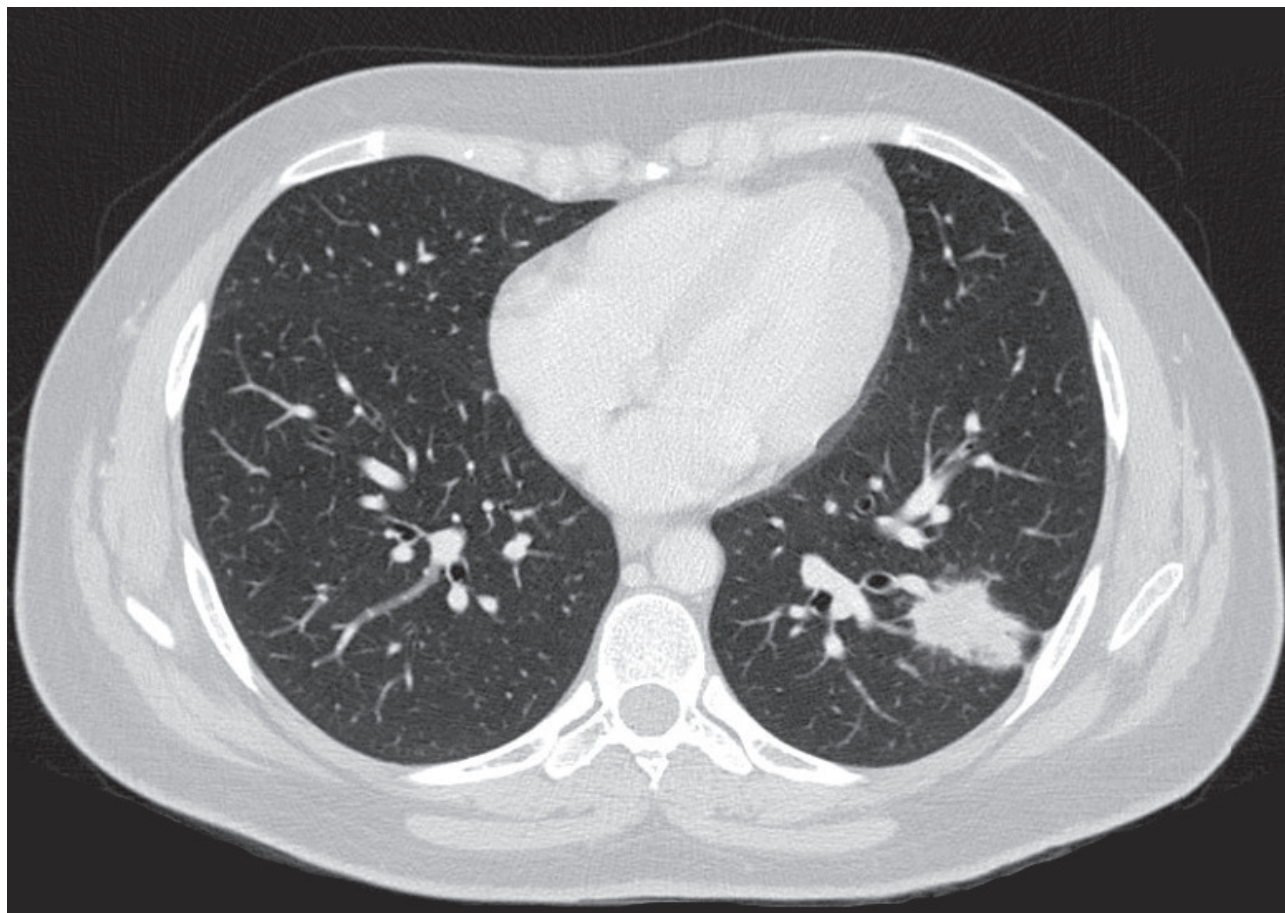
CT scan revealing a single peripheral spiculated nodule with 3 cm on the left lower lobe
